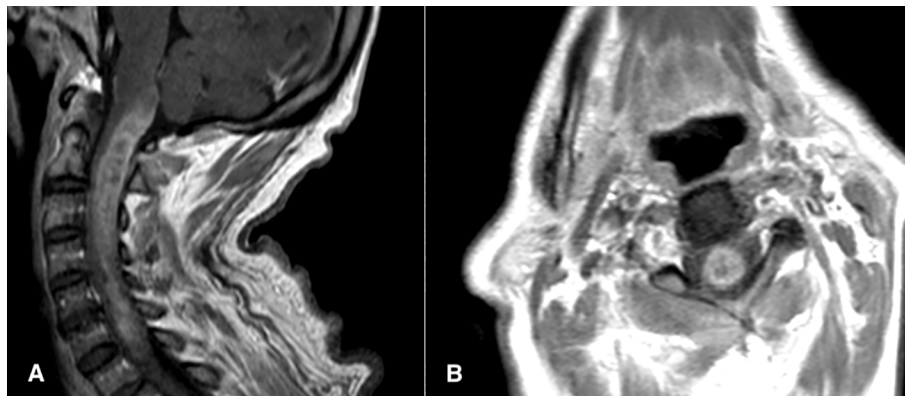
Patient 4 preoperative images: Sagittal (A) and axial (B) post-contrast T1 spinal MRI demonstrate an invasive cervical lesion, from C0 to C7 with inhomogeneous contrast enhancement.
